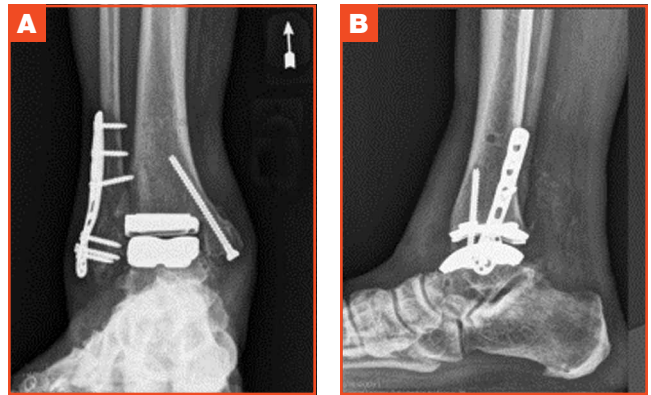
Case 1: (A) Anteroposterior and (B) lateral radiographs showing ankle replacement after surgery.
